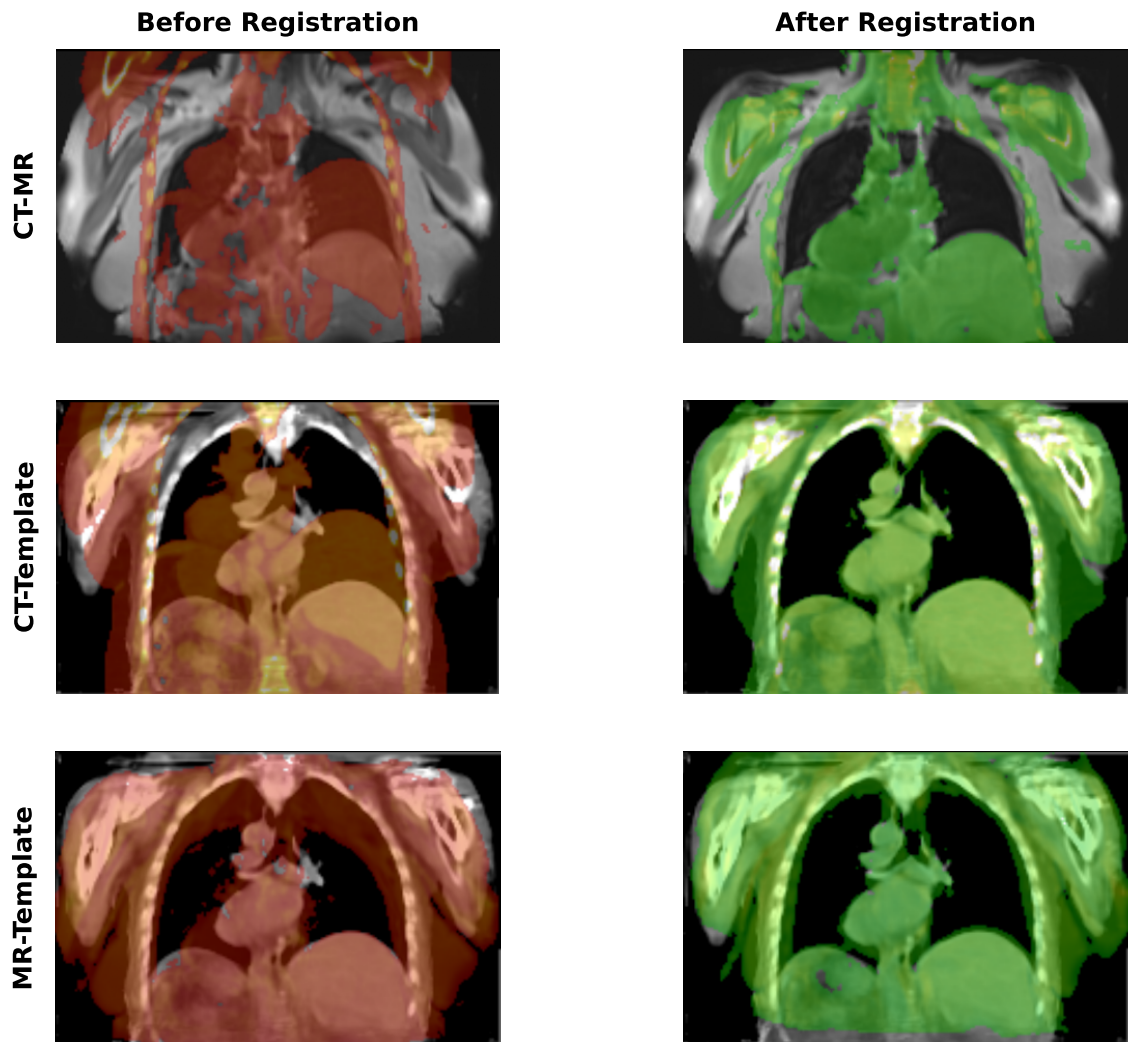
Registration overlay comparisons. Rows show (top to bottom): CT-to-MR, CT-to-template, and MR-to-template registrations. Columns show (left) before registration and (right) after registration. Post-registration overlays demonstrate improved alignment of anatomical structures.
